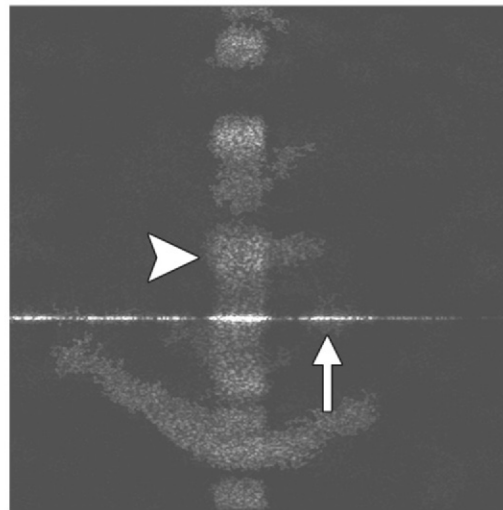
A zipper artifact may directly affect the calibration image. (a) Axial T1-weighted parallel MR calibration image shows a zipper artifact (arrow) with frequency encoding along the anterior-posterior axis. (b) Top section of a global sensitivity map created by summing the calibration images from each coil element shows that the orientation of the zipper artifact (arrowhead) is flipped and that the artifact is not masked by the algorithm used to create the sensitivity map. (c) Top section of the T1-weighted parallel MR image seen in a shows the artifact (arrow) and an absence of masking (arrowhead) near the artifact on the calibration image.
